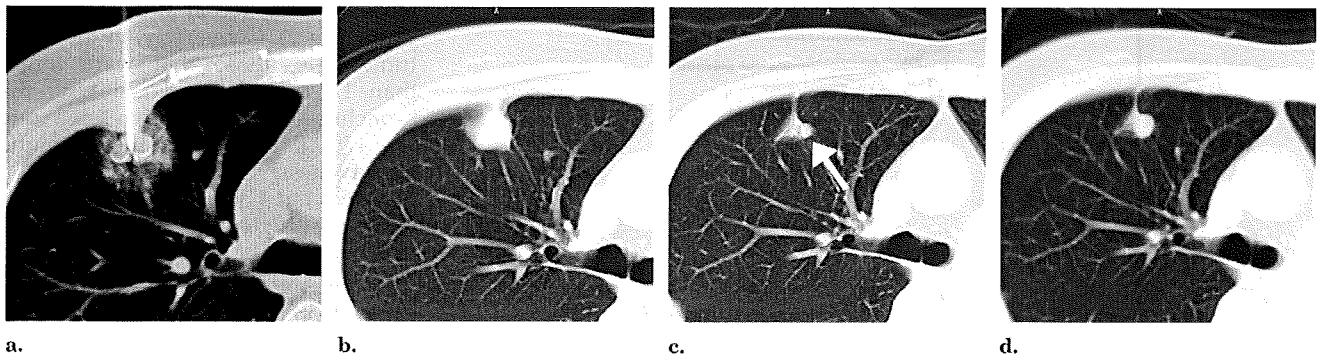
Images from a 55-year-old woman with metastatic lung cancer from uterine leiomyosarcoma. (a) Chest CT image during RF ablation for a metastatic tumor 1.3 cm in long-axis diameter in the right upper lobe shows that ground-glass attenuation surrounds the tumor entirely. (b) Chest CT image 2 months after RF ablation shows that the ablated lesion enlarges compared with the tumor before RF ablation. (c) Chest CT image 5 months after RF ablation shows that the ablated lesion remarkably decreases in size, but a small nodular focus (arrow) appears at its periphery, indicating local progression. (d) Chest CT image 6 months after RF ablation shows that the nodular focus enlarges substantially.
